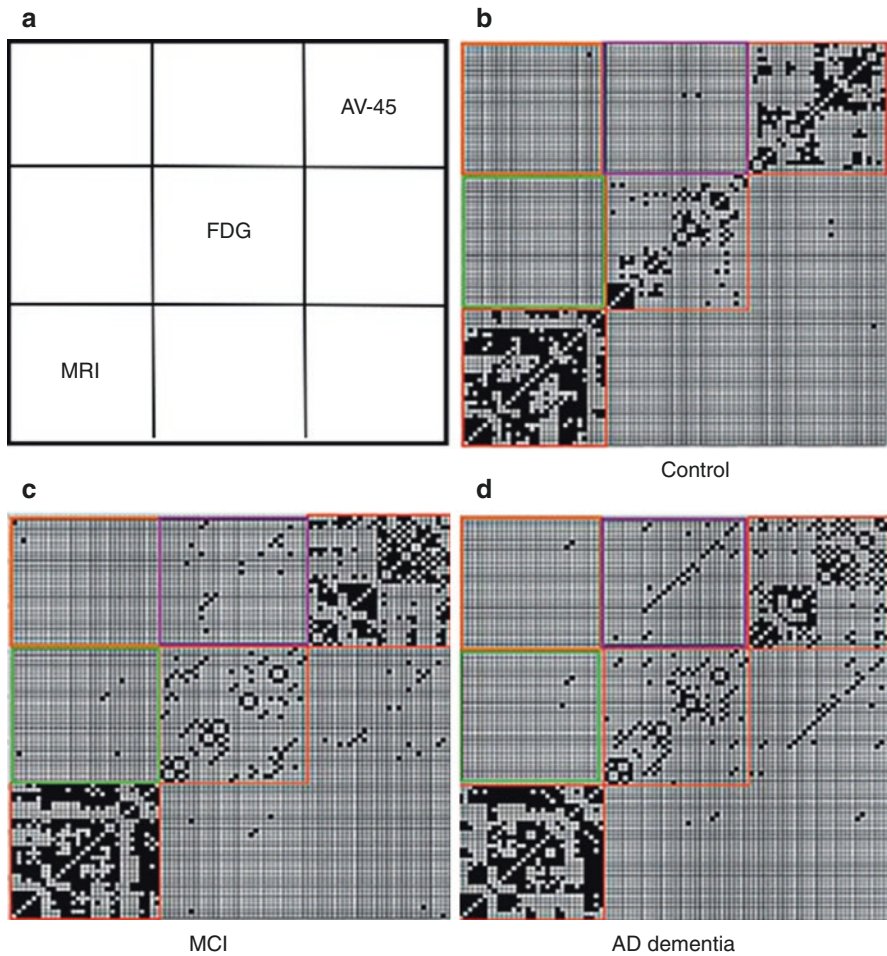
Brain connectivity models using SICE based on multimodal data. (a) Matrix indicative of the subdivision into submatrices (30×30 ROIs) of the data corresponding to AV-45 (Florbetapir-PET), FDG-PET, and MRI (brain volumes). The figure shows the model for normal control (b), MCI (c), and AD dementia (d). (Images adapted from Li et al. (2018))
